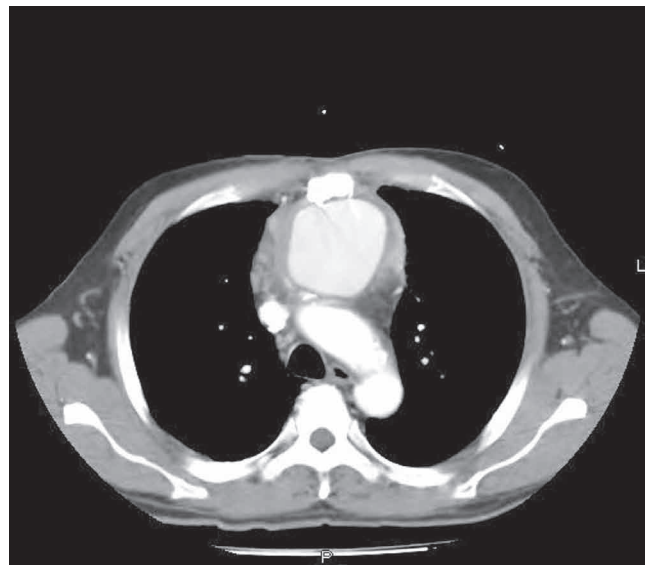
CT Scan Oblique Image Showing the Pseudoaneurysm.
